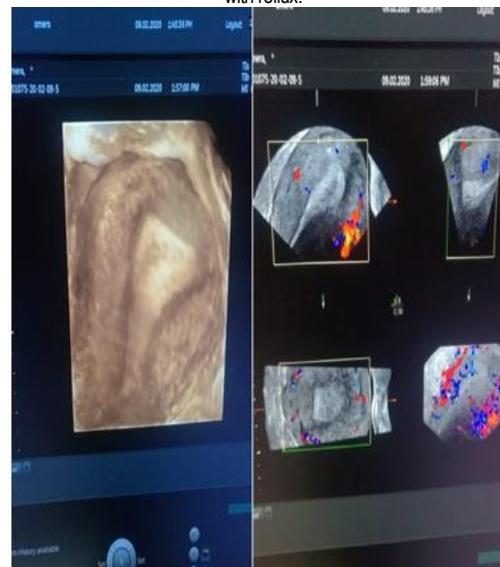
Power Doppler 3D demonstrating Para uterine varicosities.
